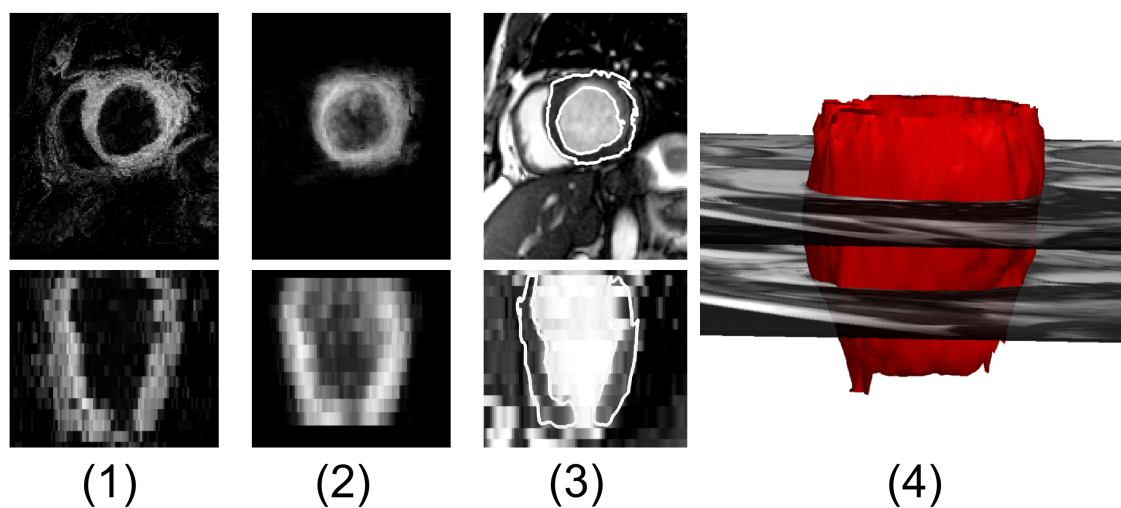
Two classification layers are used for left ventricle segmentation with random forests. (1) first layer posterior probability is used as a weight map for context aware MRI intensity standardization and cardiac pose normalization, (2) second layer is then used for a more confident left ventricle segmentation, (3) second level posterior probability isocontour overlay, (4) volumetric visualisation of the obtained segmentation.
